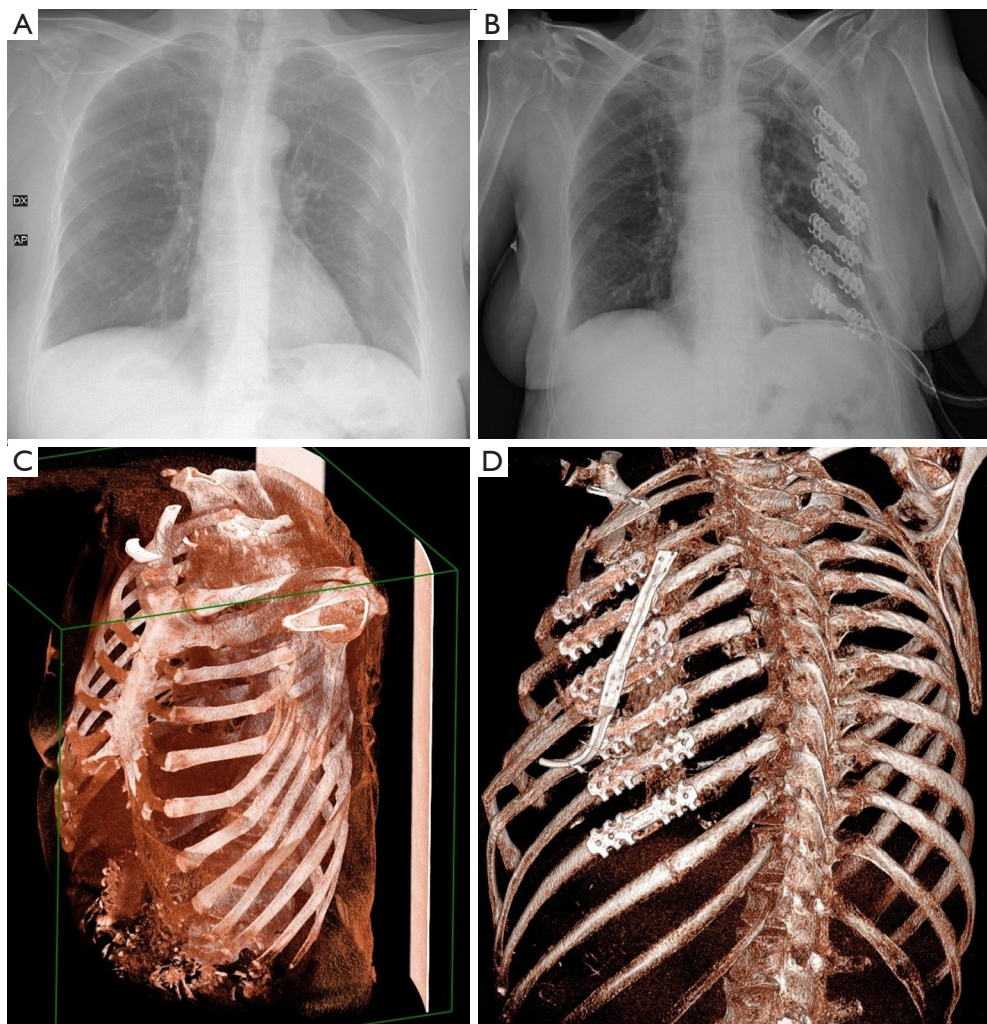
Preoperative and postoperative X-ray (A,B) and 3D-CT (C,D) of the thorax reconstruction. CT, computed tomography; 3D, three-dimensional.
